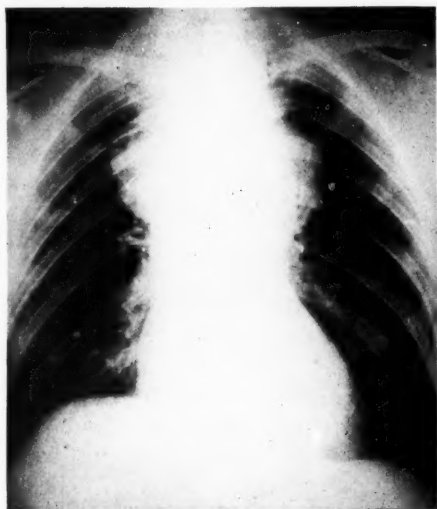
X-ray of patient's chest, postero-anterior view.
